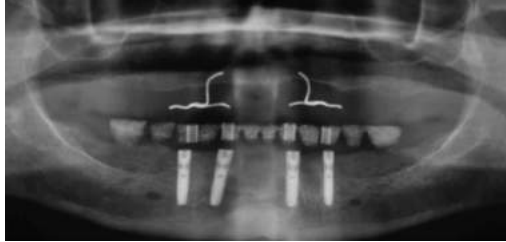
X-ray after implantation with mucosa-born drilling template in situ
